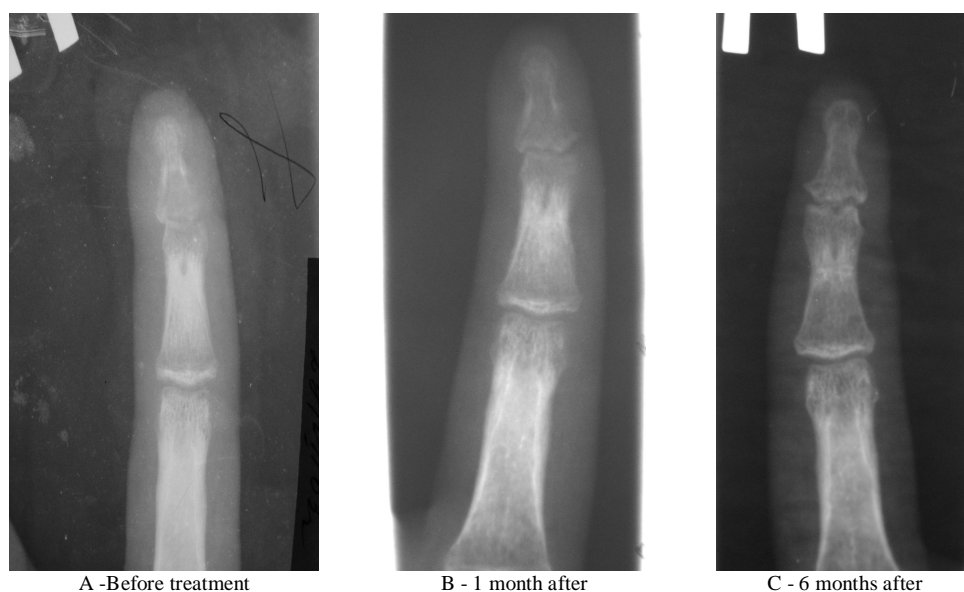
Roentgenographs of patient L, 14 y.o., with osteoarticular panaritium.
